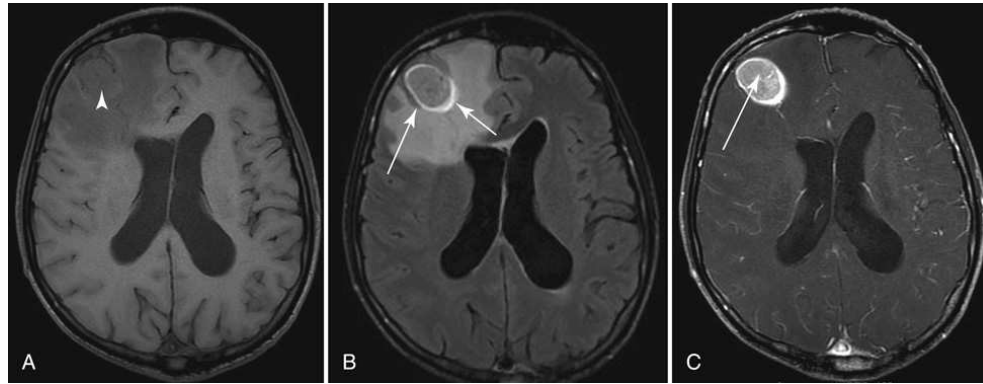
Use of IV gadolinium contrast medium for lesion enhancement in axial images of the brain. (A) T₁-weighted sequence. A single brain lesion (*arrowhead*) is seen as a focal area of low signal intensity in a large area of edema. The borders of the lesion are difficult to delineate. (B) FLAIR image. Areas of high signal (*arrows*) represent tumor and surrounding edema. (C) T₁-weighted image obtained using similar parameters after IV administration of gadolinium. Lesion borders and size (*arrow*) are much more conspicuous.
